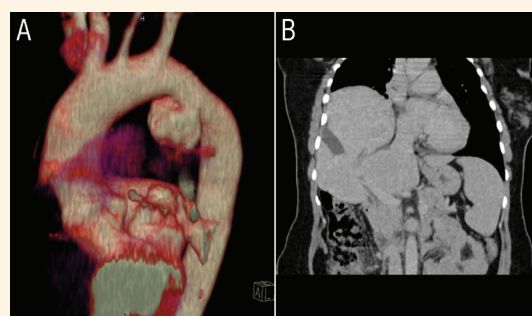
(A) Computed tomography scan showing an incidentally detected saccular pseudoaneurysm at the aortic *isthmus*, and (B) right diaphragmatic hernia containing the right lobe of the liver in a 37-year-old female patient, nine years after initial trauma.
